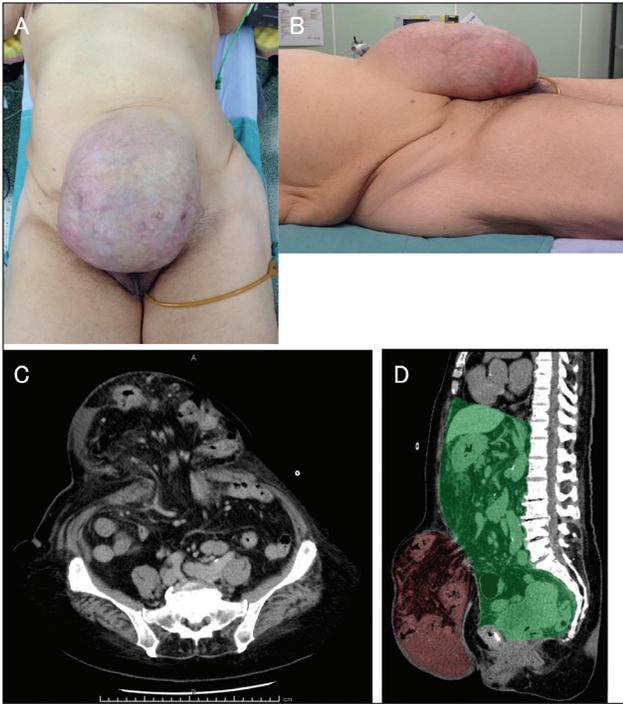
(A and B) Preoperative physical observations: an incisional abdominal hernia the size of an adult head, along a lower midline scar. The skin over the hernia was thin, with erosions and ulceration, due to the long-term irreducible hernia. (C and D) Preoperative abdominal computed tomography: 6.5L of abdominal cavity (green area) and 3.8L of hernia sac volume (red area)
